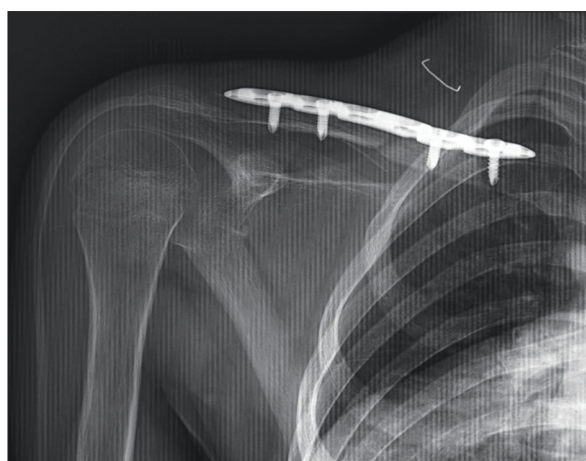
Early postoperative X-ray of the right clavicle
